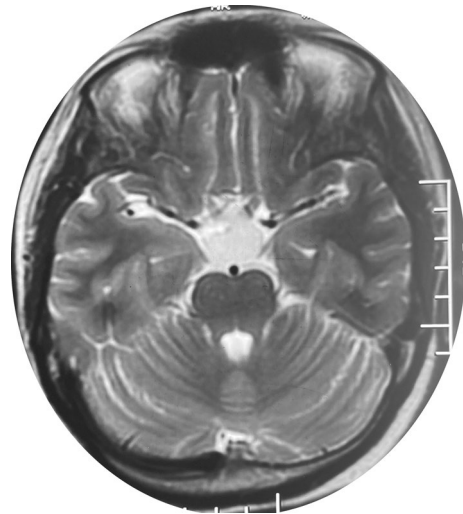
MRI brain T2 axial image showing the hyperintense suprasellar lesion
